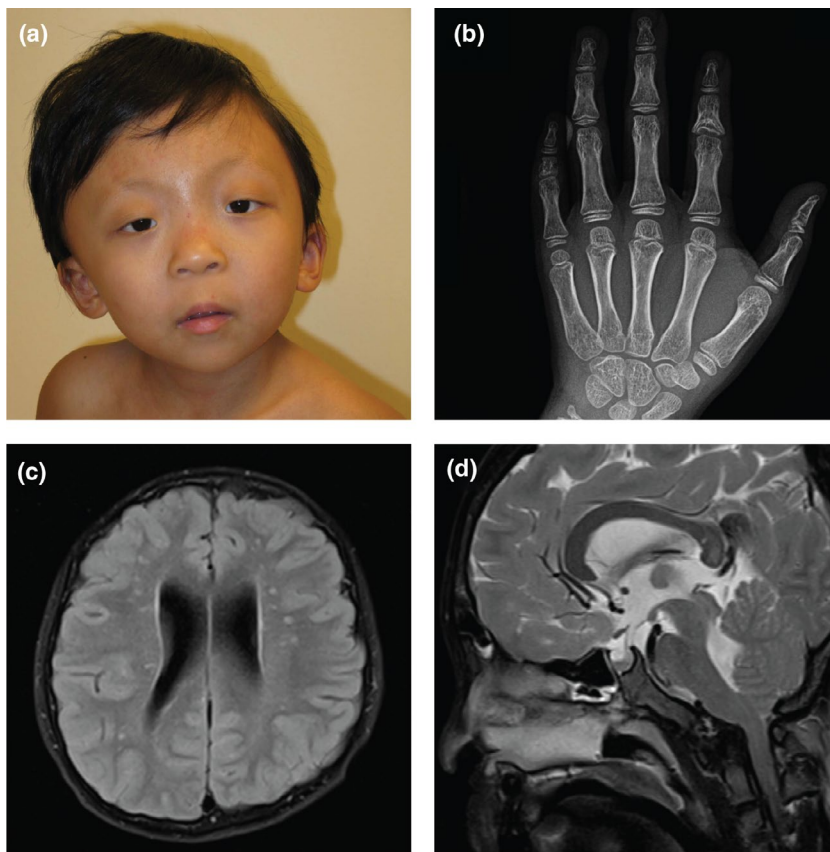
Facial features and clinical imaging of the proband. (a) Facial profile of the proband revealing distinct features. (b) Hand x-ray displaying delayed bone age. (c,d) Brain MRI revealing heterotopia, a dysmorphic corpus callosum and brainstem, and a small pituitary
